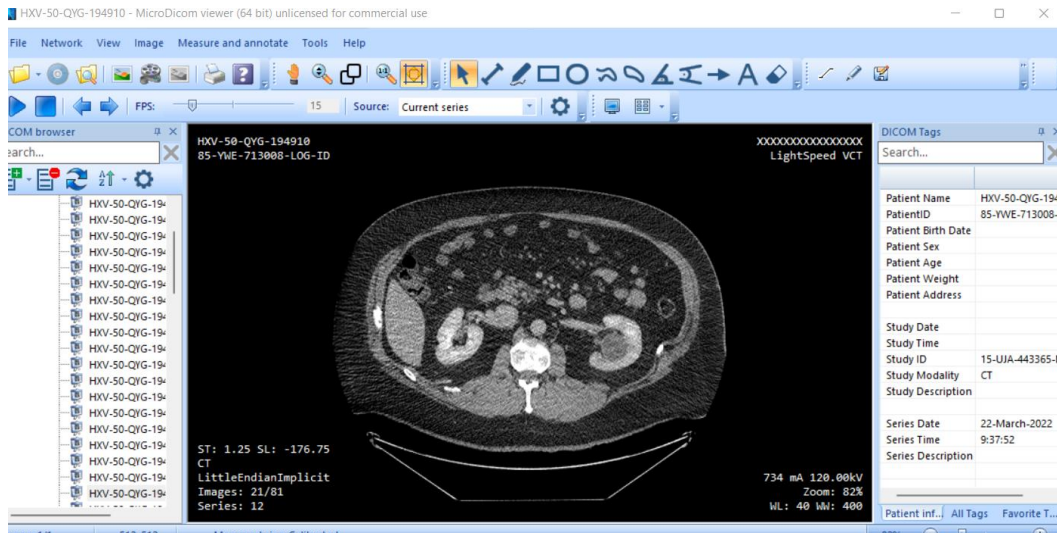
Viewing of CT slice
